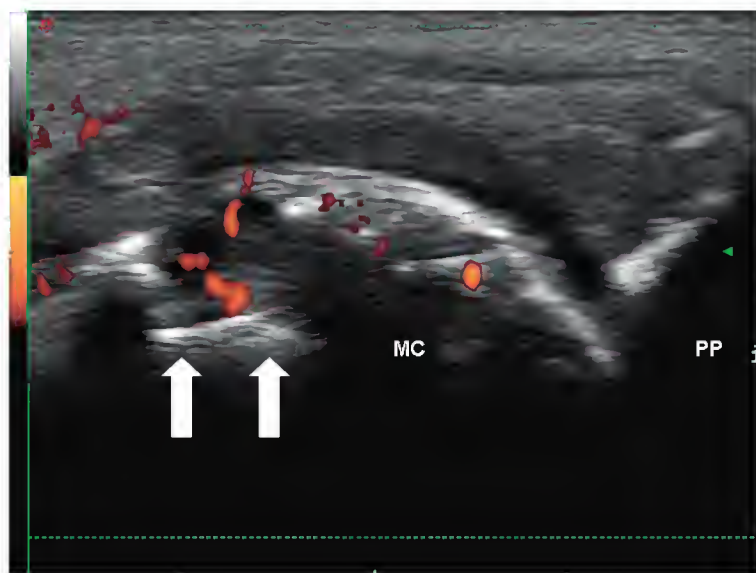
Bone erosion in rheumatoid arthritis. Longitudinal view of second metacarpophalangeal joint shows generalized cortical irregularity in the metacarpal (MC) head with a large, well-demarcated cortical break (arrows) with associated hypoechoic synovial thickening and power Doppler signal within the erosion indicating synovitis. PP, proximal phalanx.
